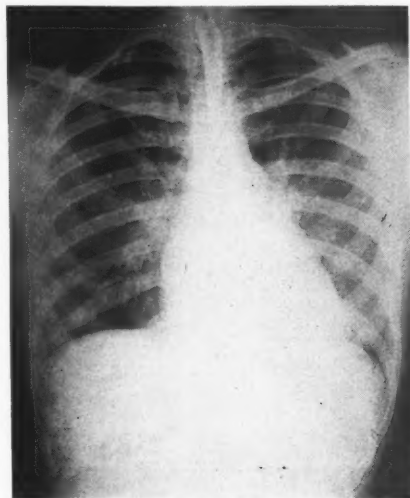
Case 4.* (S. N.) Chest roentgenogram, P-A view, May 9, 1952, preoperatively. There is slight cardiac enlargement. The aortic knob is small. The pulmonary artery segment is enlarged and convex. The left auricle is enlarged. The hilar areas are prominent. The left lower hemithorax is hazy.
